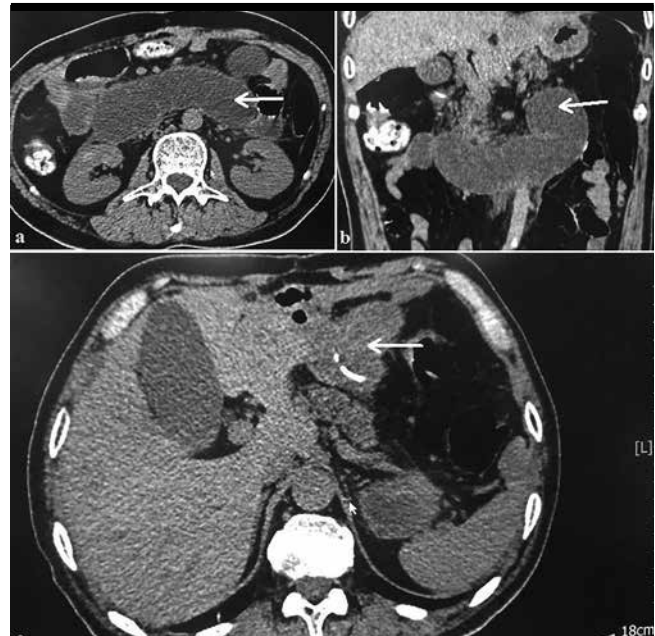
a-c. Images of computed tomography (CT) findings before the procedure: Afferent loop (intestinal canal) was dilated and emerged as effusion (axial view) (a); C-shaped intestinal loop (white arrow) (b); Thickened anastomosis wall (white arrow), mild edema of pancreas and gallbladder enlargement (c)
